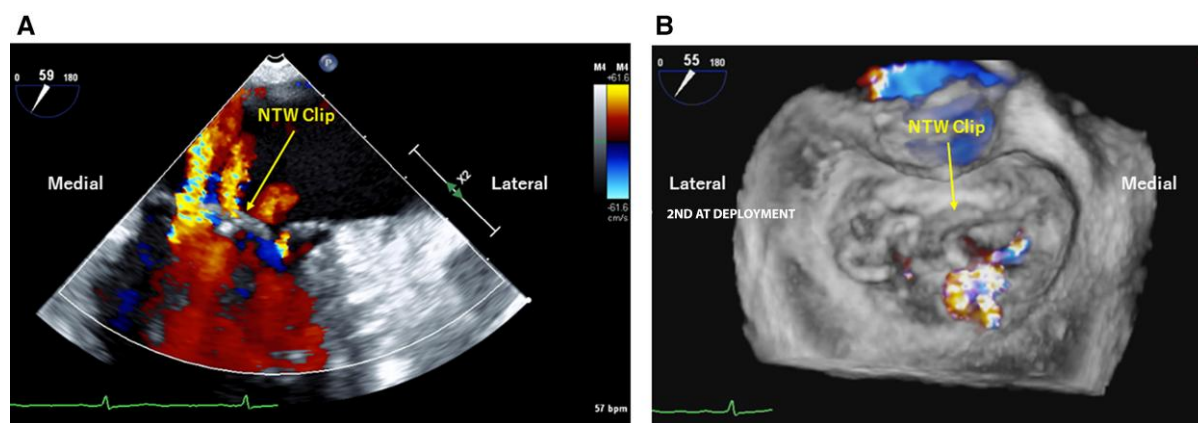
Transoesophageal echocardiography images after the first clipping. (A) Mitral regurgitation is reduced after clipping. (B) Improvement of mitral regurgitation is confirmed on three-dimensional colour imaging.
